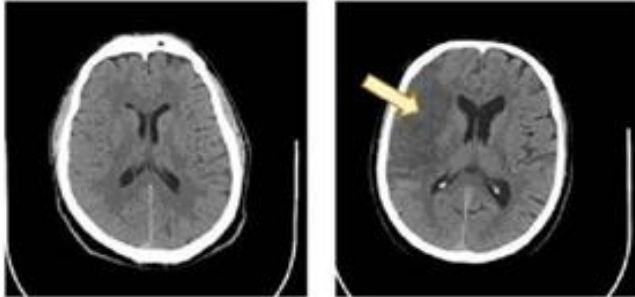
Normal CT brain slice (Left) and Cerebral Infarction slice (Right)
